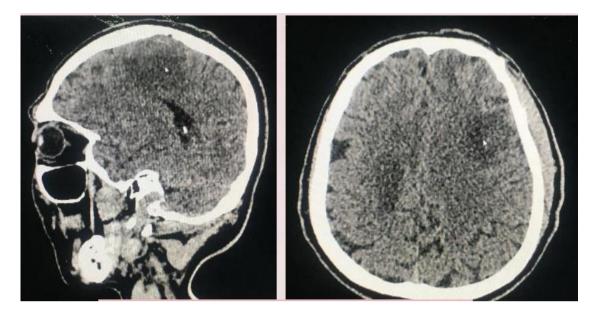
The results of the Pre-Contrast Head CT-scan in the patient.
